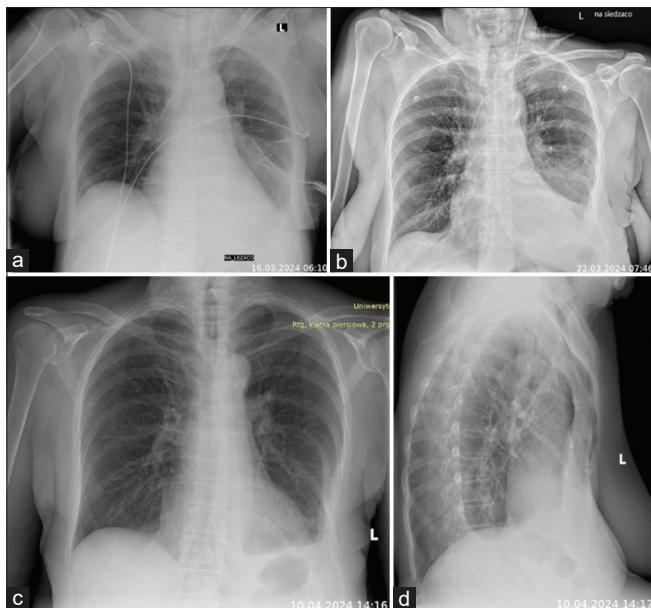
(a) Anteroposterior chest X-ray (CXR) performed 30 min after drainage, demonstrating complete reexpansion of the left lung. (b) Anteroposterior CXR after drain removal. (c and d) Follow-up anteroposterior (c) and lateral (d) CXRs taken 3-week postprocedure
